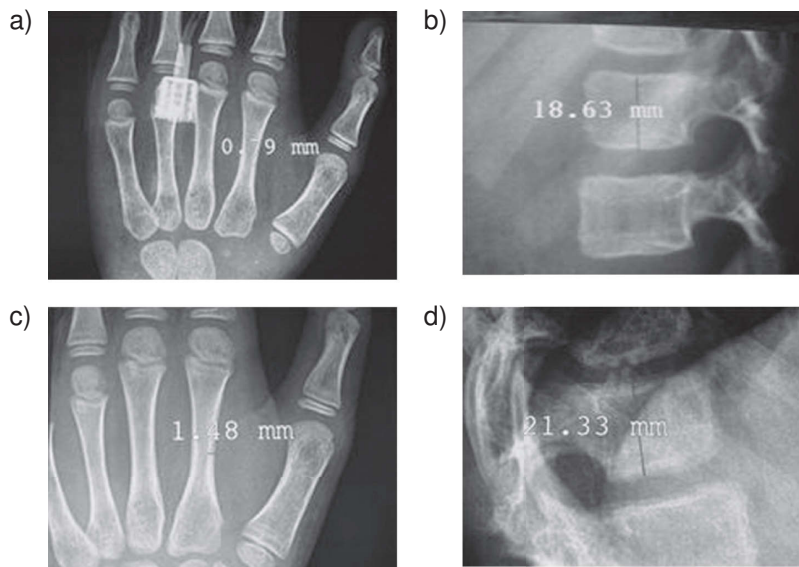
X-ray Images showing measurement of the effect of bisphosphonates on children with OI treated with pamidronate. a) and b): x-ray of left hand with measurement of cortical thickness in the 2nd metacarpal (a) and height of the first lumbar vertebra (b) prior to bisphosphonate therapy. c) and d): the same measurements after treatment, where increased cortical thickness (d) and increased height of the first lumbar vertebra (e) are noted.
